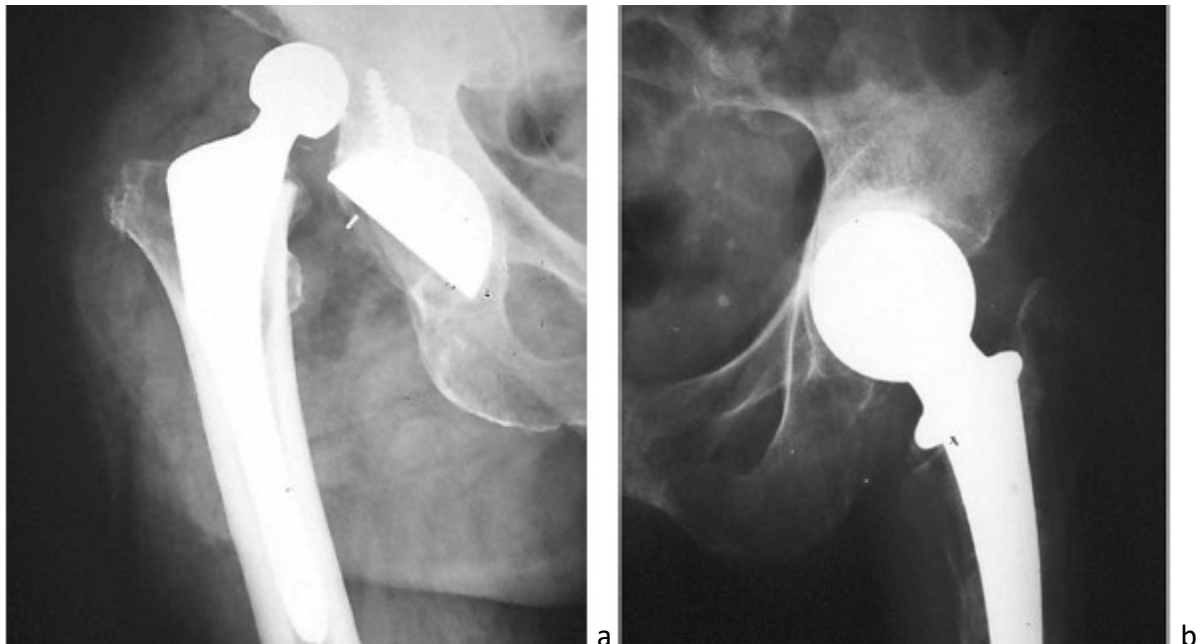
Radiographs of dislocation following total hip arthroplasty (a), and acetabular erosion following hemiarthroplasty (b). Image reproduced with permission (email correspondence).
